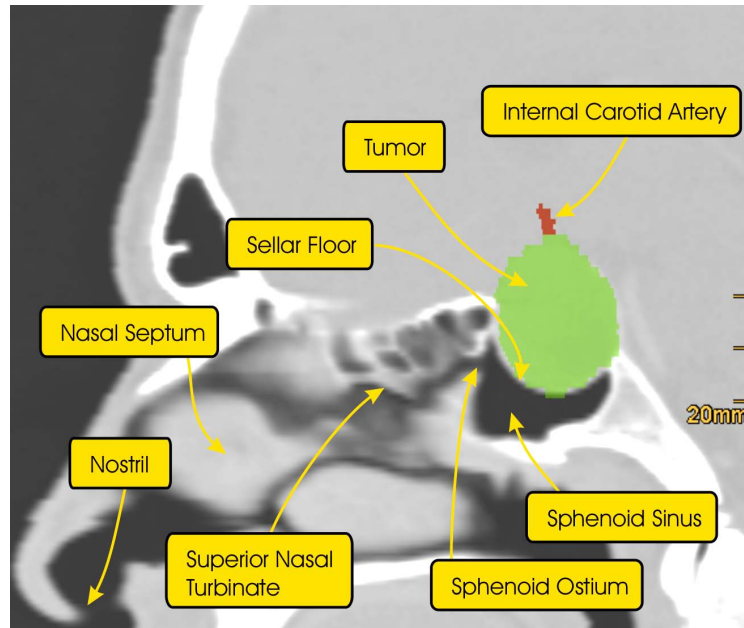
Anatomy as captured by a CT. A sagittal slice through a CT data set of a head.
